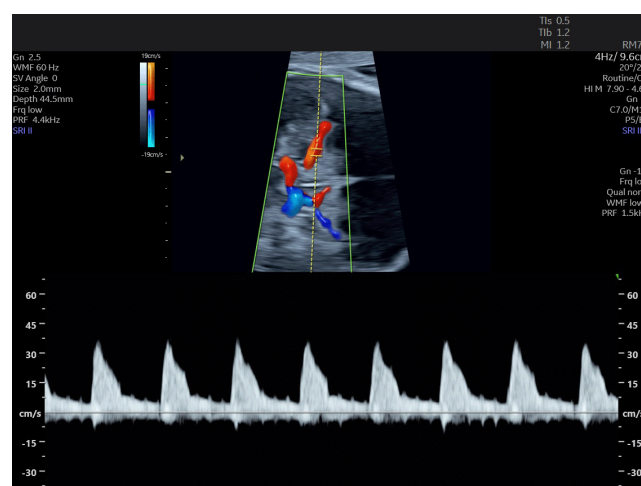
Doppler waveform from middle cerebral artery obtained transabdominally in third trimester.
